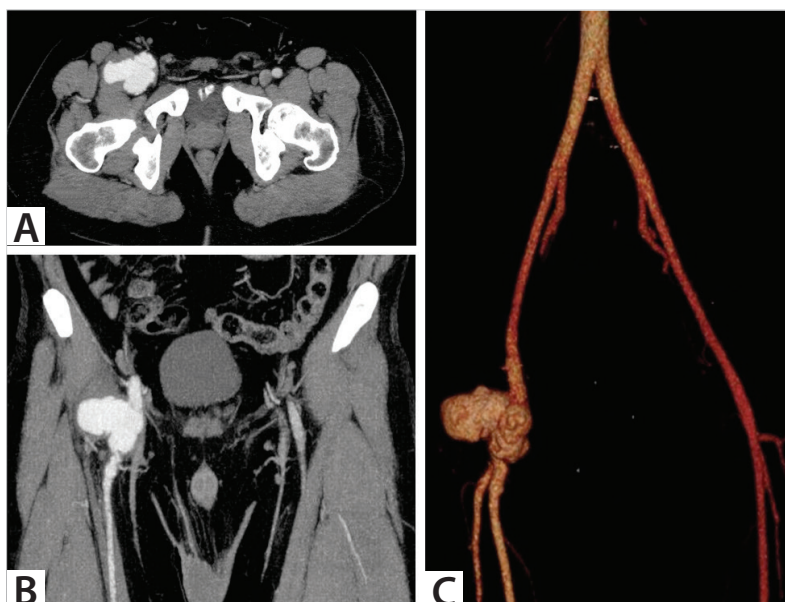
A. In the arterial phase extremity CT angiography, pseudo-aneurysm is observed in the right common femoral artery with an irregular wall in the right common femoral artery in the arterial phase at the level of the femoral neck. B. In the coronal CT reformat maximum intensity projection image, the contours and extension of the pseudo-aneurysm in the common femoral artery. C. In 3-D CT reformat image, the relationship between pseudo-aneurysm, neck and common femoral artery can be observed.
